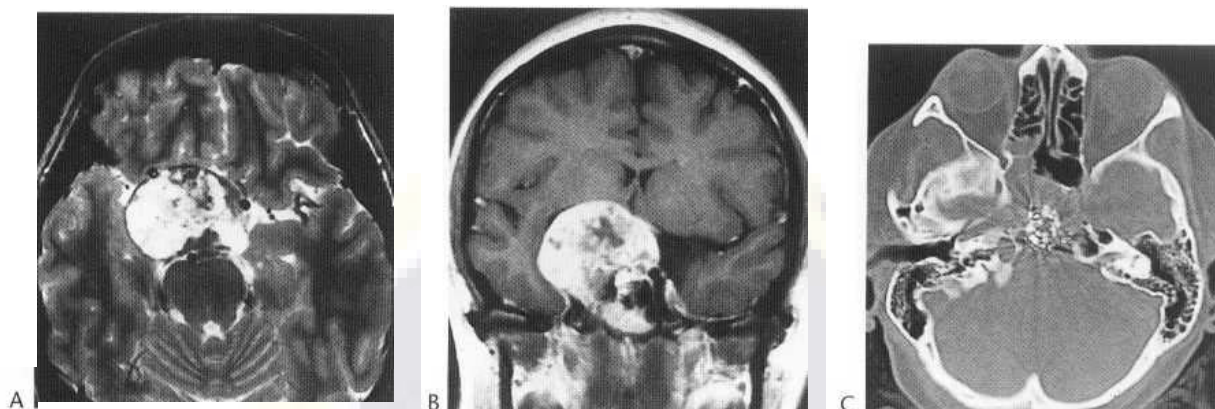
A large heterogeneous T_2 signal eccentric suprasellar chondrosarcoma (A) displaces the terminal internal carotid arteries. (B) On the postcontrast coronal T_1 -weighted image the mass involves the clivus and shows heterogeneous enhancement. The axial CT (C) shows that the mass is partially calcified.
